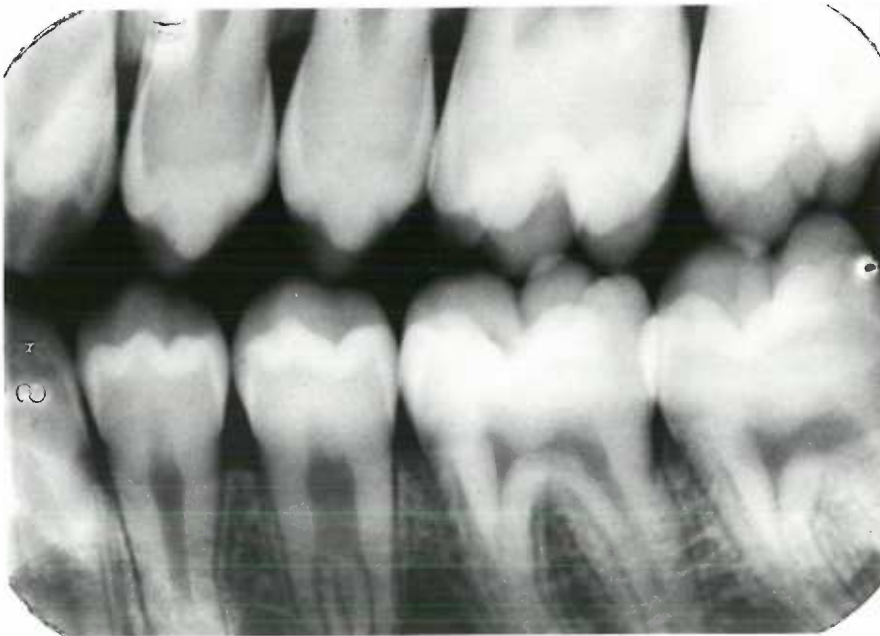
Patient 4. Age fourteen years, bitewing radiograph shows no alveolar bone loss.
